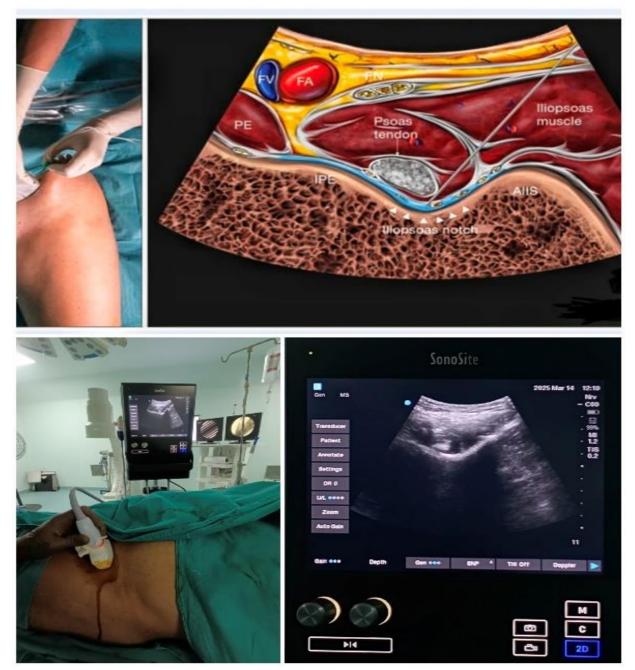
PENG block; reverse ultrasound anatomy with needle insertion inplane. FV, femoral vein; FA, femoral artery; FN, femoral nerve; PE, pectineus muscle; IPE, iliopubic eminence; AIIS, anterior inferior iliac spine.
